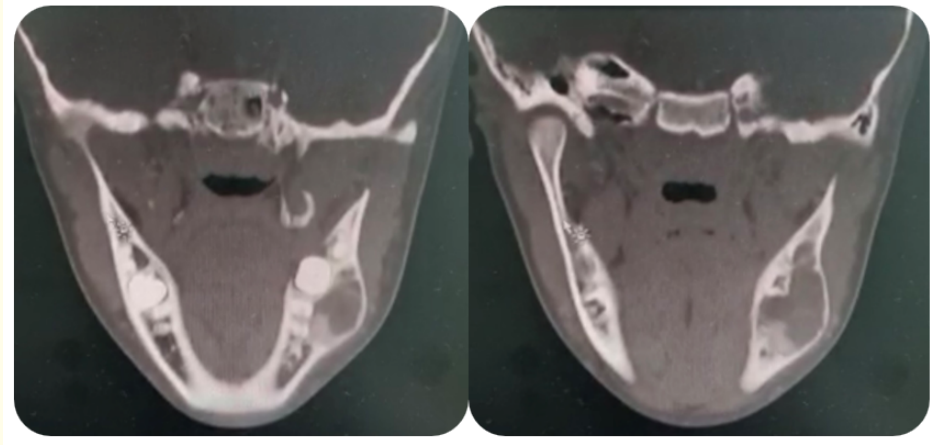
Cone beam computed tomography axial view.
